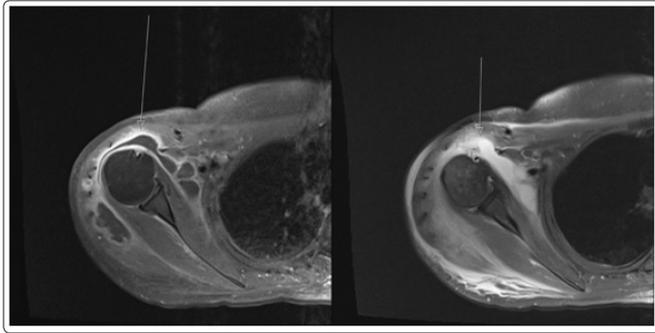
MRI axial views of the right humerus showing diffusely abnormal enhancement indicative of abscesses along the humerus and surrounding skeletal muscles.
